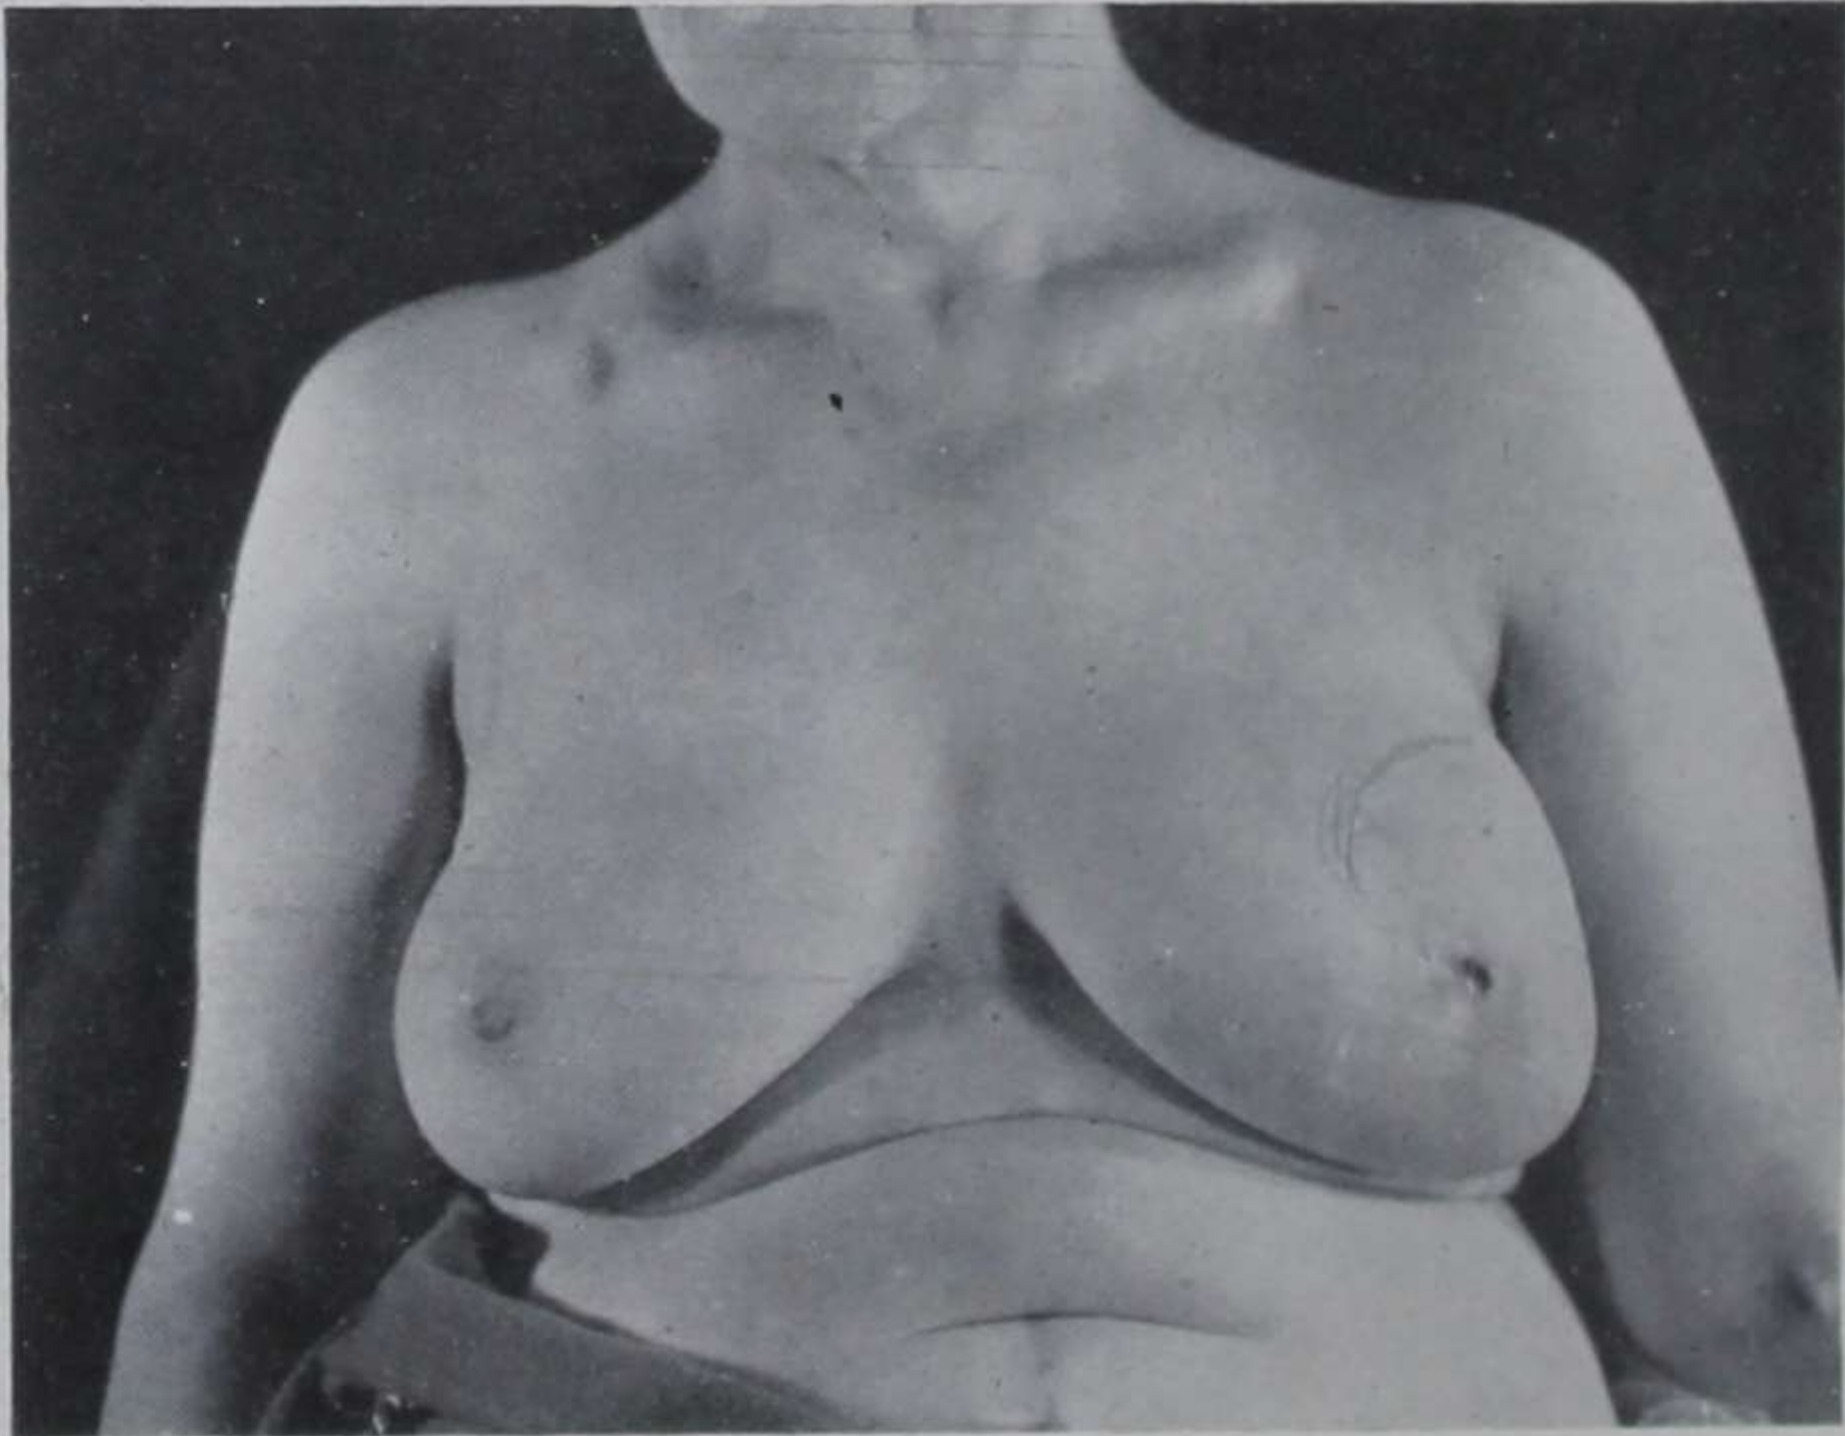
Advanced carcinoma of left breast in a woman aged 56. Condition on first attendance. Infiltration *en cuirasse* of the skin, involvement of axillary and supraclavicular lymph-nodes, and radiographic evidence of pulmonary deposits. Patient noted "stiffness" of the left breast while swimming 3 months previously but took no notice till the skin covering the breast became discoloured and the left arm swollen (Stage 4).
